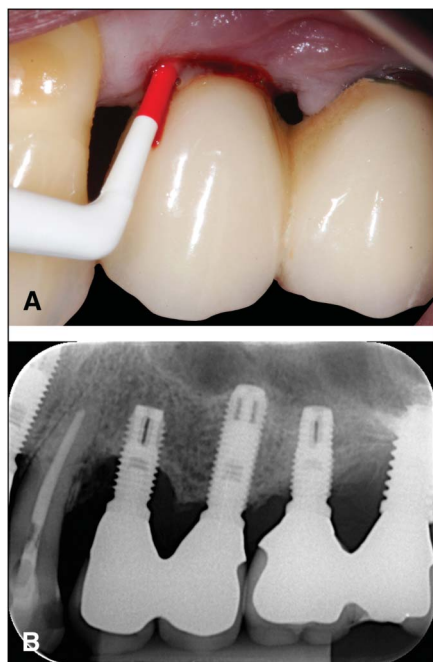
Peri-implantitis affecting the implant at position 24. A, Clinical signs of peri-implantitis, including increased probing depth, bleeding on probing, and suppuration. B, Preoperative periapical x-ray showing a typical peri-implantitis crater-like defect.
